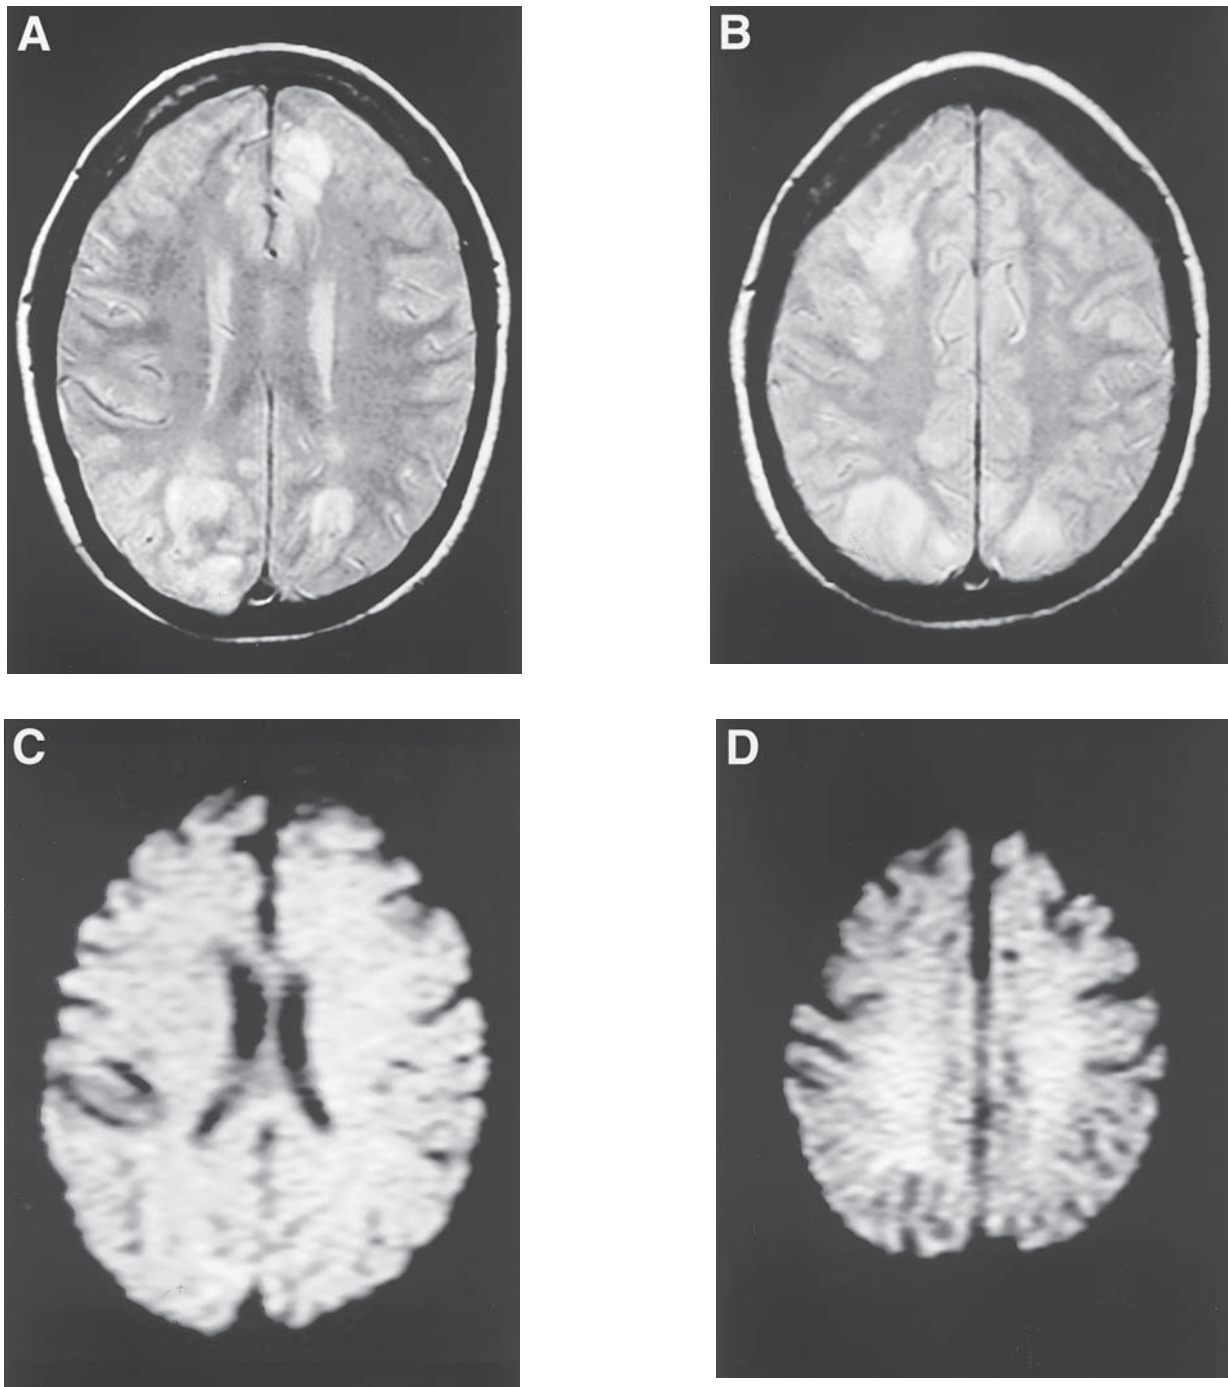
MRI in a patient with tacrolimus neurotoxicity. Note diffuse white matter hyperintensities with no specific predilection for the posterior hemispheres (A and B). The diffusion-weighted MR (C and D) was normal (further mapping showed increased ADC levels consistent with vasogenic edema).
